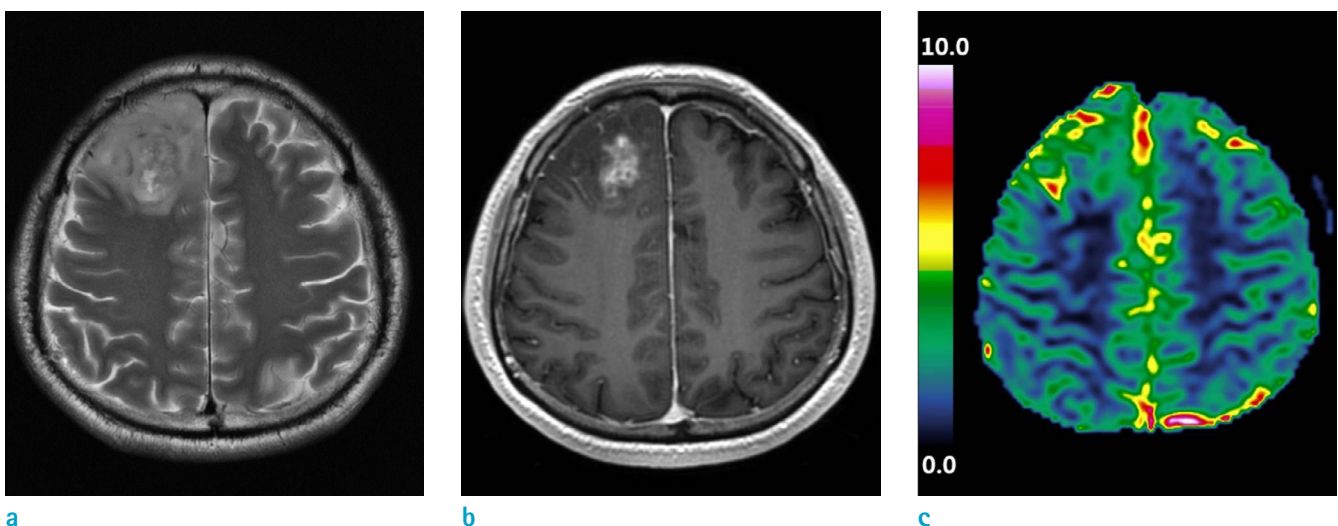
A 47-year-old male with glioblastoma in the right frontal lobe. (a) T2-weighted image, (b) T1-weighted contrast-enhanced image, and (c) rCBV map are shown. The mean rCBV value measured from the enhanced part of the tumor was 1.95. Molecular analysis revealed both MGMT promoter methylation and 1p19q codeletion. The overall survival was 81 months.
